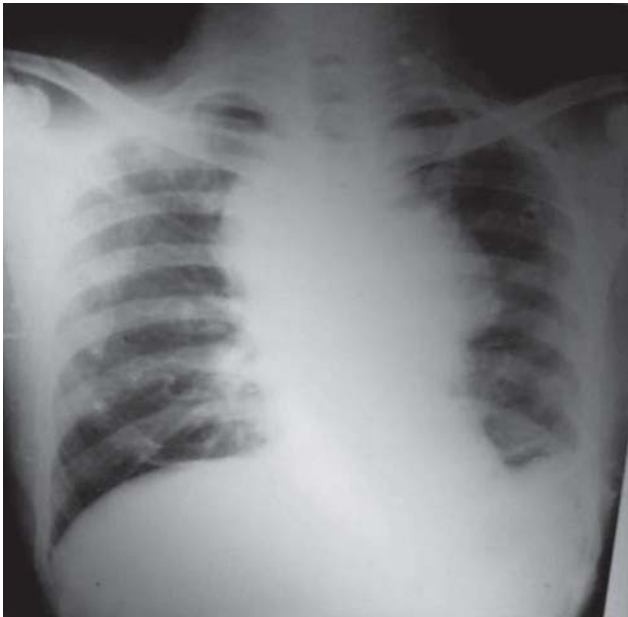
Chest radiograph repeated after 3 months, showing widening of mediastinal shadow involving the right paratracheal-parahilar and left parahilar areas and partial resolution of previous tubercular lesions in the right lung field.
